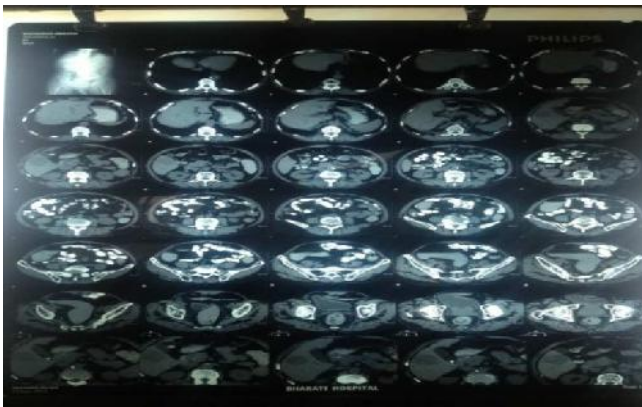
CT abdomen showing a well defined mass in liver.
